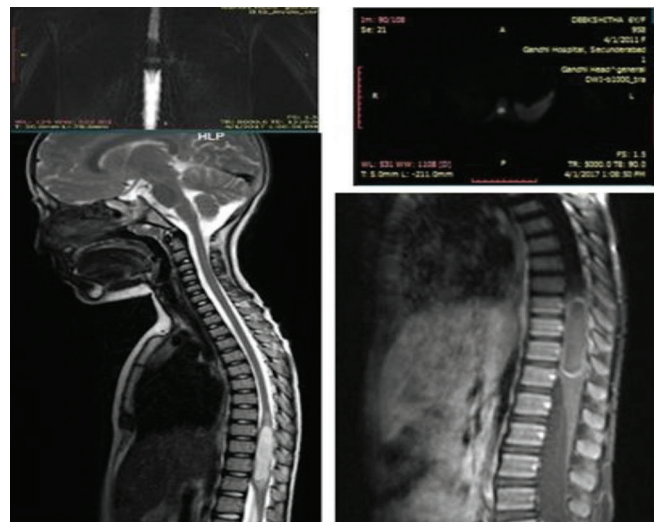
6 yr old girl with back pain. Spinal cord enlargement extending from D9 to D12 with 5x1 cm well defined intramedullary T2 hyperintense lesion showing restriction on DWI. Post contrast lesion is showing peripheral enhancement at proximal and distal aspect with central non enhancing area. Imaging diagnosis: intramedullary neoplasm
